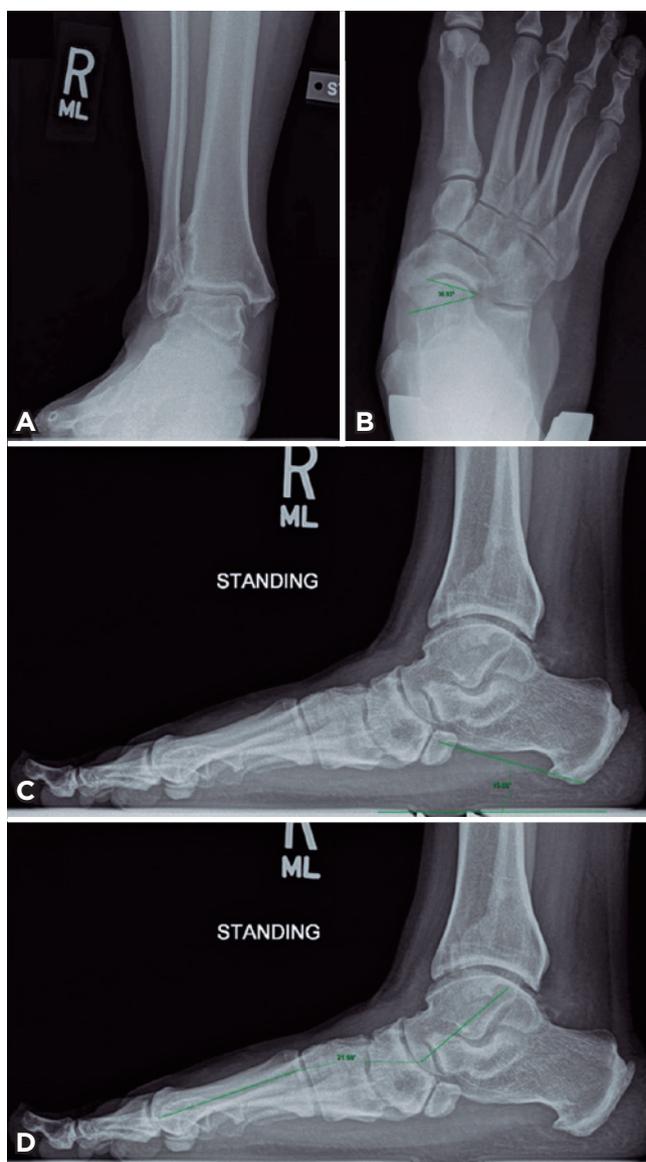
Preoperative radiographic series demonstrating absence of ankle tilt (A), talonavicular angle (B), calcaneal pitch angle (C) and Meary's angle (D).
